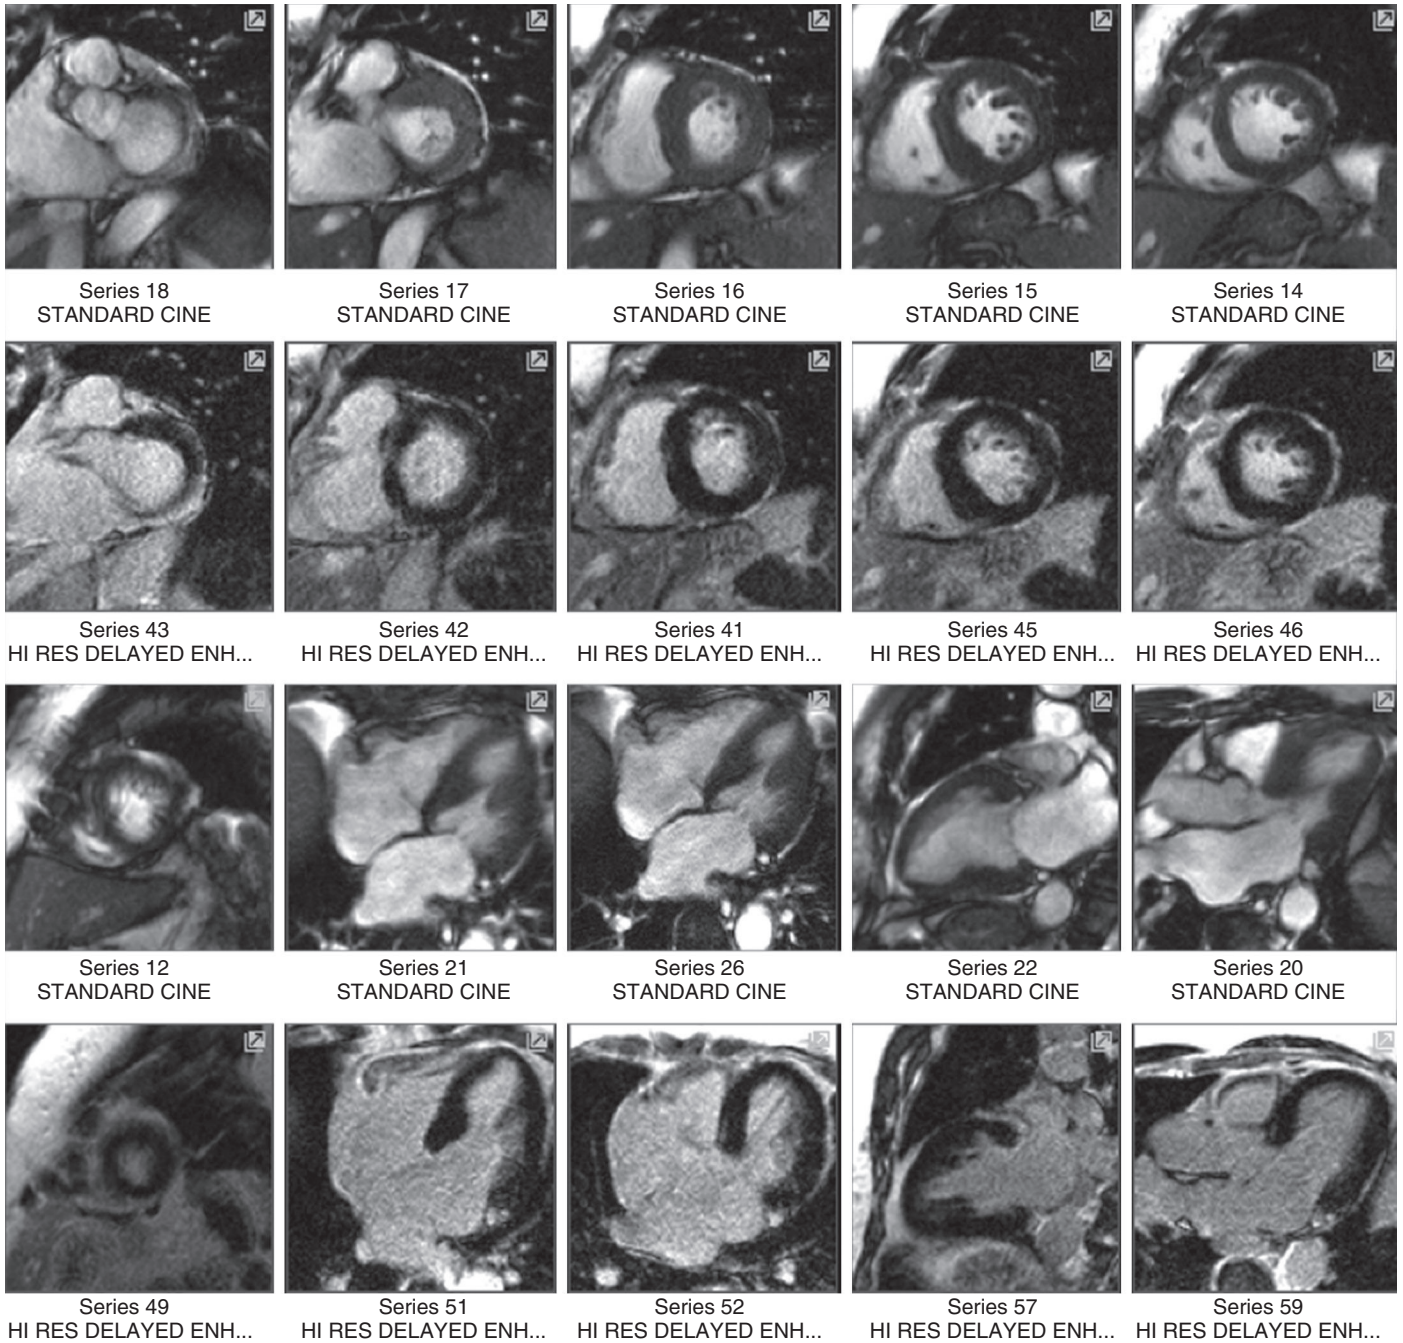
e2 A screen capture from a viewing workstation that provides simultaneous evaluation of the cine and delayed-enhancement images. Side-by-side viewing of the spatially matched cine and delayed-enhancement cardiac magnetic resonance images is vital in image interpretation. For an additional presentation of this image, [click here](#).
